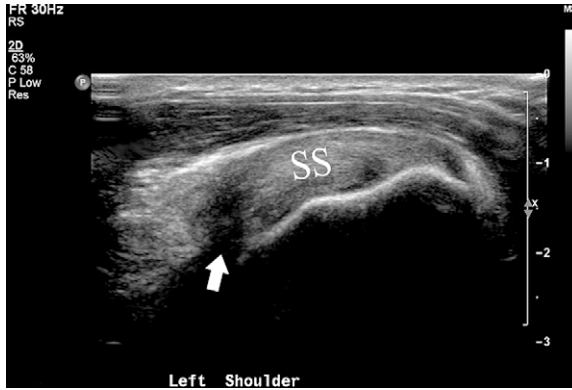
Ultrasound image demonstrating an articular-side tear (*arrow*) at the medial footprint of the supraspinatus tendon insertion. SS, supraspinatus. (Courtesy of R. Adler, MD, New York, NY.)
